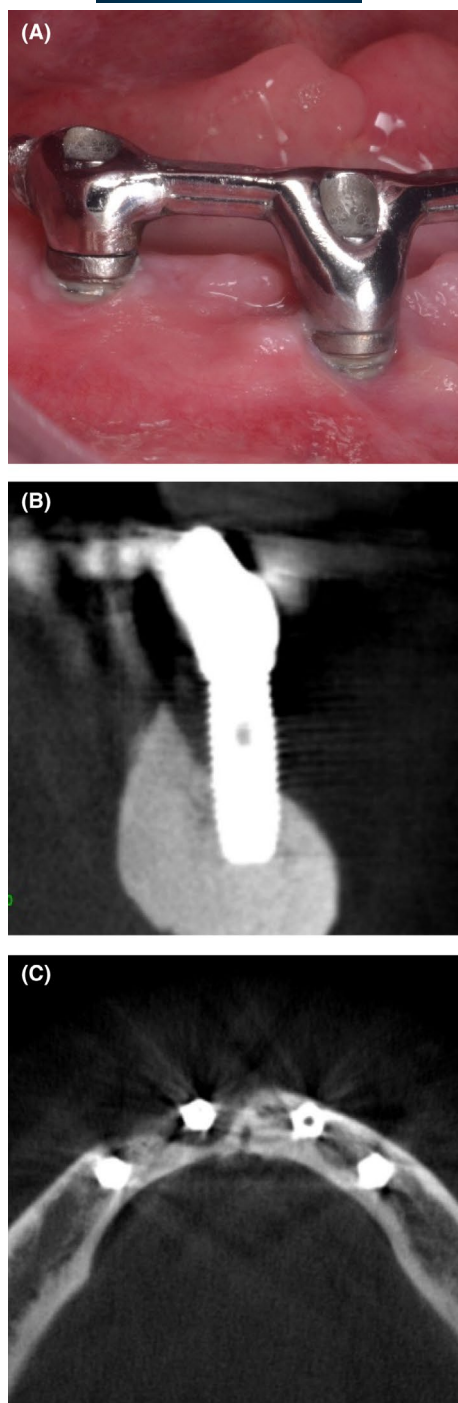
(A) One of the mandibular implants presented with pocketing, inflammation, and suppuration consistent with peri-implantitis. (B) The sagittal view of the CBCT shows the bone loss on the buccal and an angular bone defect on the lingual. (C) The corresponding axial view of the CBCT shows the relatively buccal position of the affected implant in the line of the arch, resulting in a thin buccal bone wall which subsequently underwent avascular necrosis.
